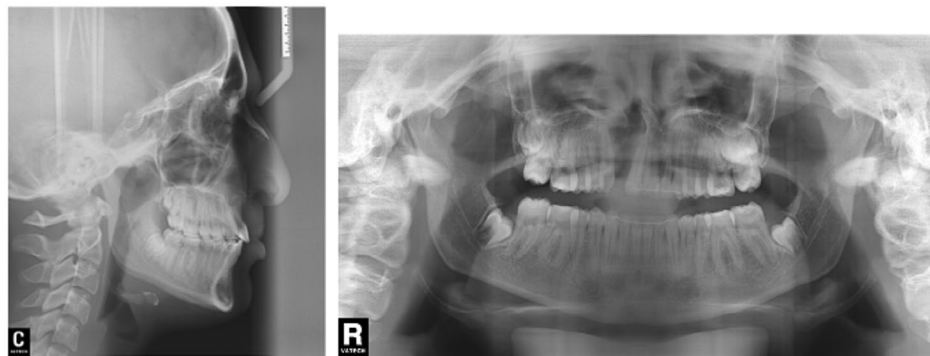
Post-orthodontic-treatment radiographs: (a) lateral cephalometric, (b) panoramic.
